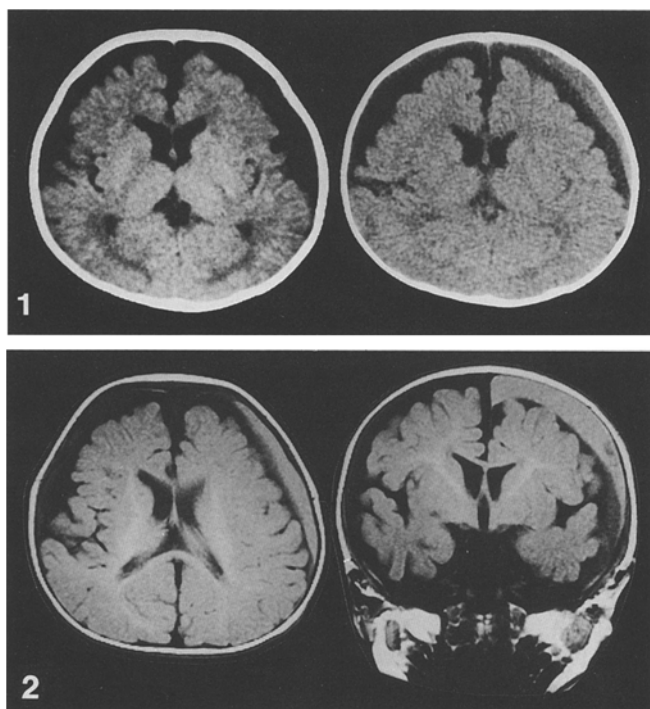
Computed tomographic (CT) scans showing infantile subarachnoid fluid collection with traumatic hematoma in a 5-month-old male infant. *Left:* CT scan obtained immediately after head trauma. *Right:* CT scan 2 weeks after head trauma shows the development of a subdural hematoma
